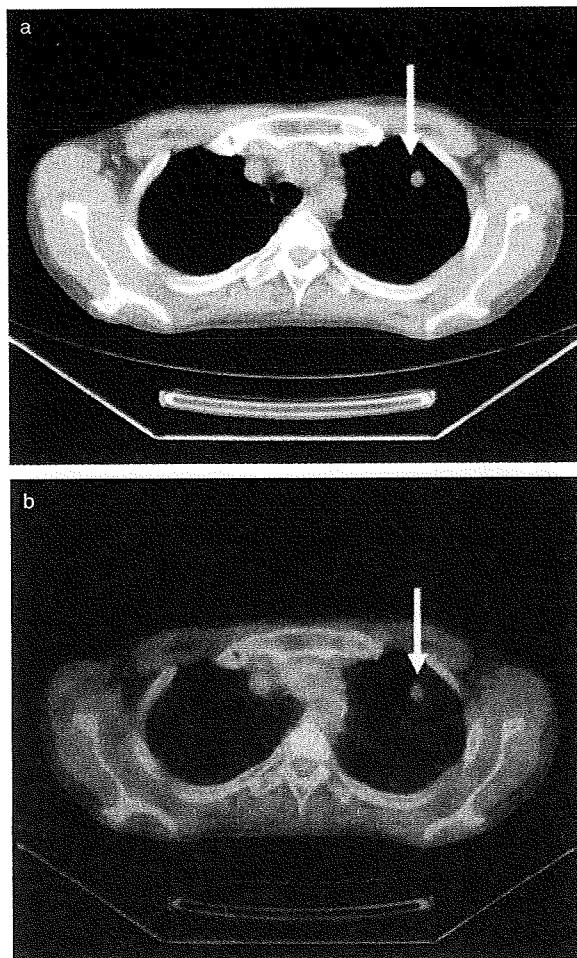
A 50-year-old male patient with hepatocellular carcinoma (HCC). (a) Multi-detector helical computed tomography (MDCT) showed lung metastasis measuring 5 mm in diameter in the left lung (white arrow). (b) The corresponding positron emission tomography - computed tomography (PET-CT) showed no accumulation of 18F-FDG in the left lung lesion.
